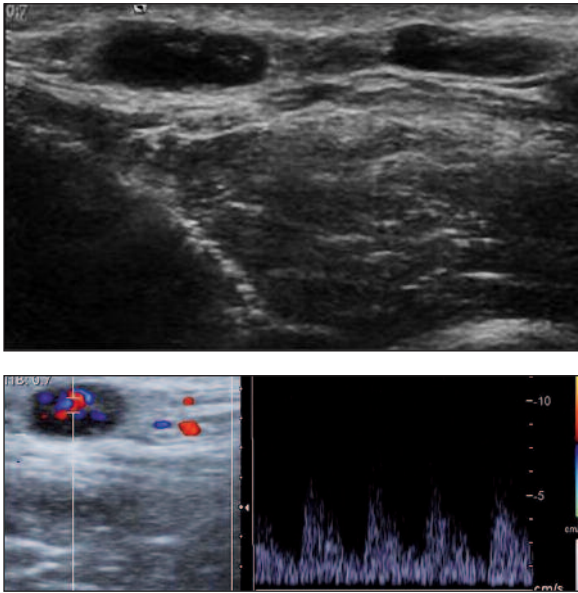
A,B: Gray scale ultrasonography (US) (A), color and Duplex Doppler US (B) images show well circumscribed solid lesions. The lesions are continuous with superficial neural structures and reveal arterial flow pattern.
